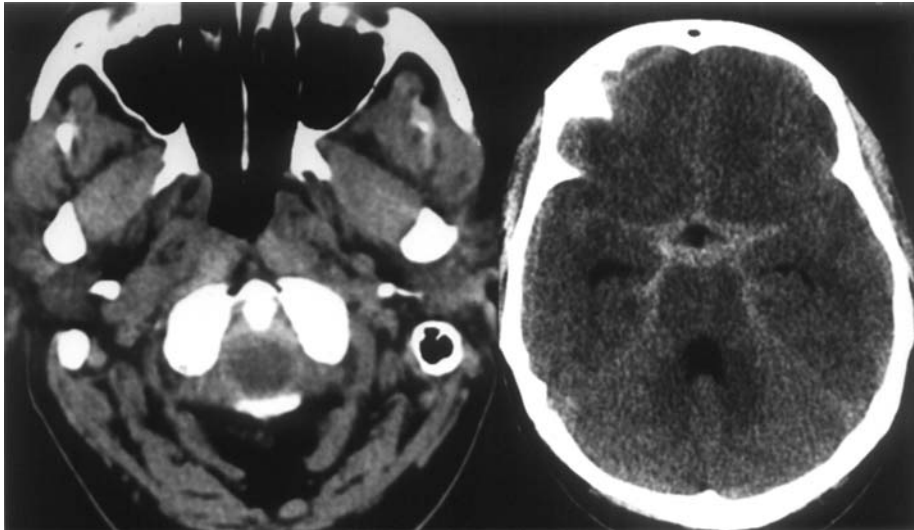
Initial plain CT with infra- and supratentorial SAH
